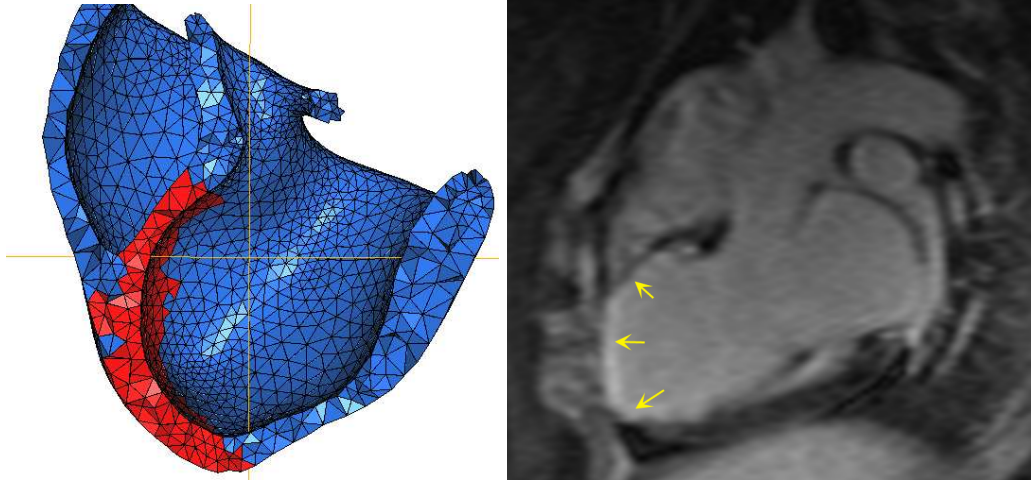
Infarct at T0+38: in the mesh (left, in red) as segmented from the late enhancement MR images (right, yellow arrows).
